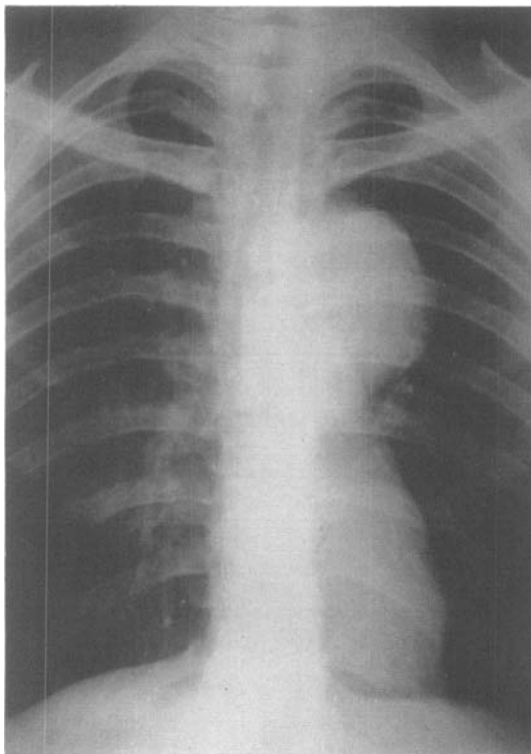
Case 3. Radiograph of chest.
